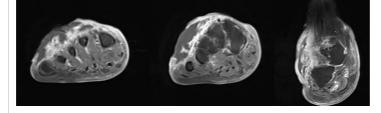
The MRI conducted at initial visit, revealed widespread soft tissue inflammation and the formation of an abscess extending from the proximal part of the metatarsal to the lateral side of the ankle.
